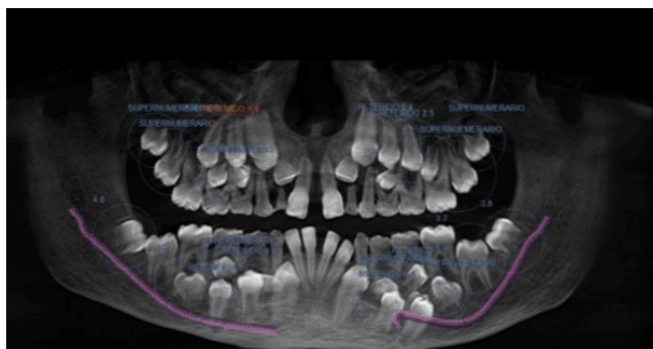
Axial computed tomography revealing numerous retained supernumerary teeth in both jaws.
